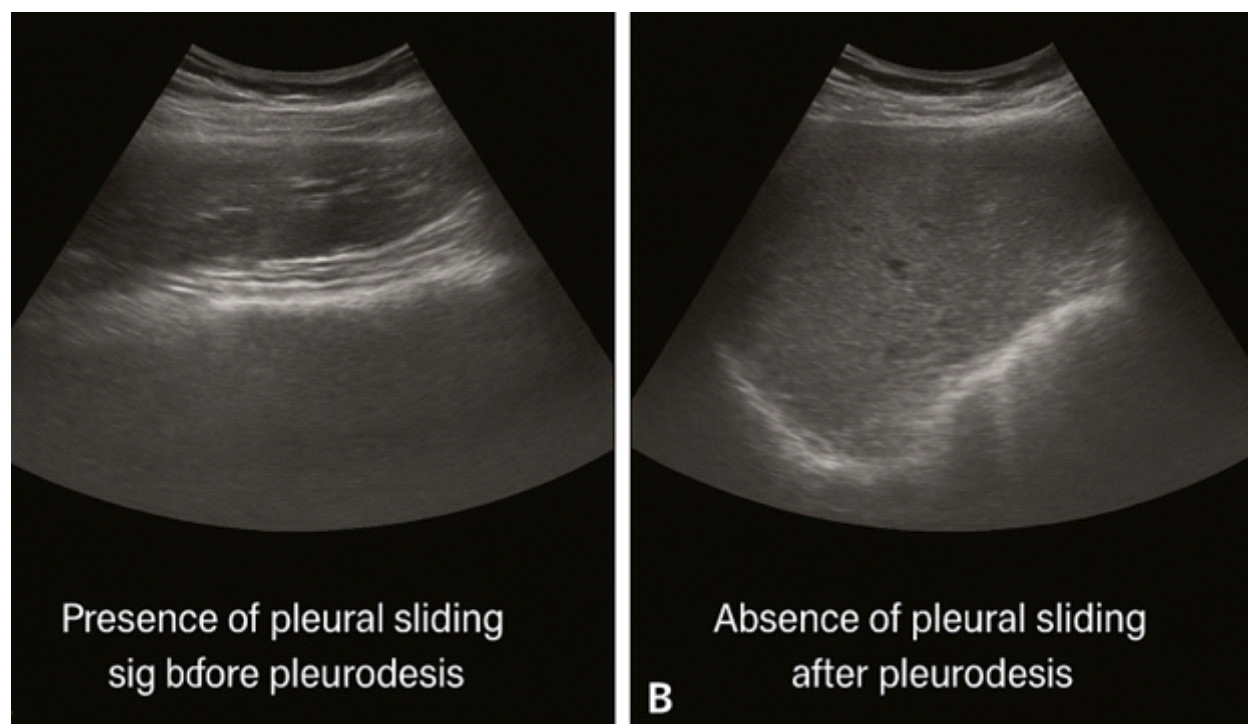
Ultrasound Images Pre- and Post-Pleurodesis. A: Presence of pleural sliding sign before pleurodesis. B: Absence of pleural sliding after pleurodesis.
